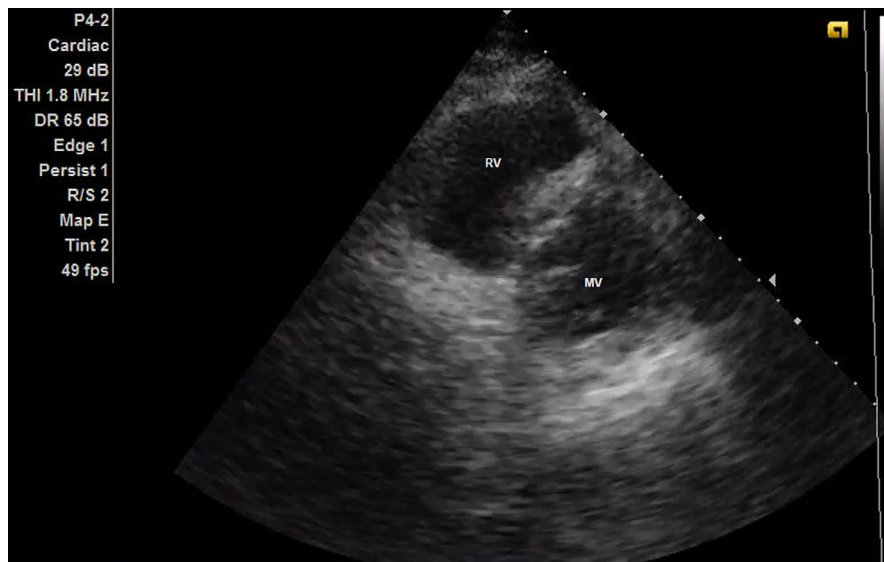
Patient's TTE after HBOT: the disappearance of the microbubbles. (TTE, transthoracic echocardiography; HBOT, hyperbaric oxygen therapy; RV, right ventricle; MV, mitral valve)
